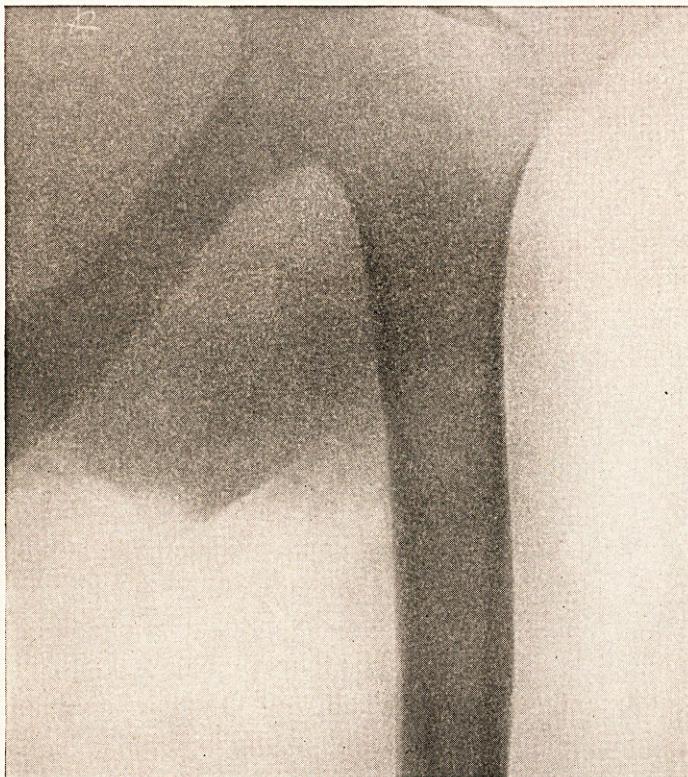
Case No. 11. X-ray of humerus showing area of rarefaction in the head of the bone.
